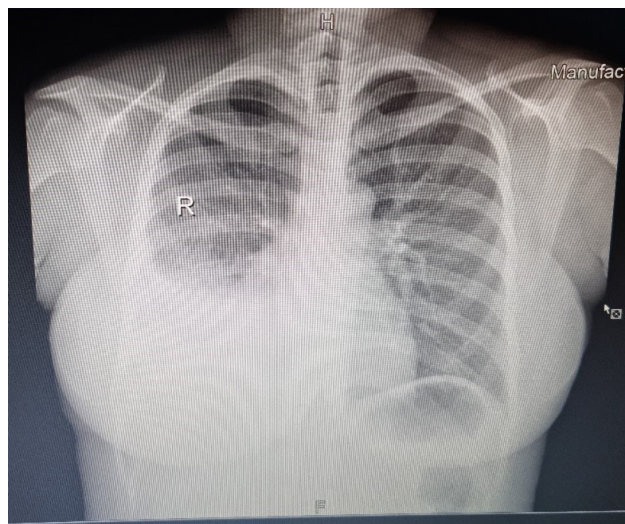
Chest X-ray of right-sided pleural effusion.
